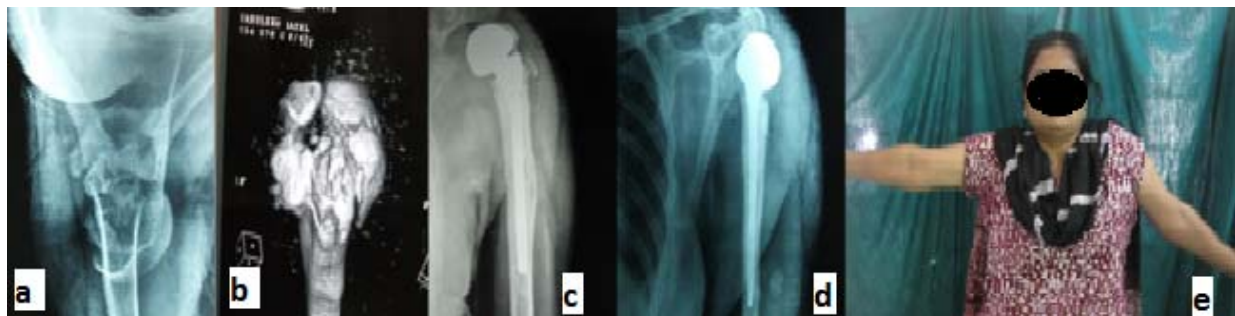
Case of Hemireplacement (a) Pre-Operative X ray Axial View (b) 3D CT Scan (c) Post-Operative AP View (d) Lateral View (e) 2 month Clinical ROM
